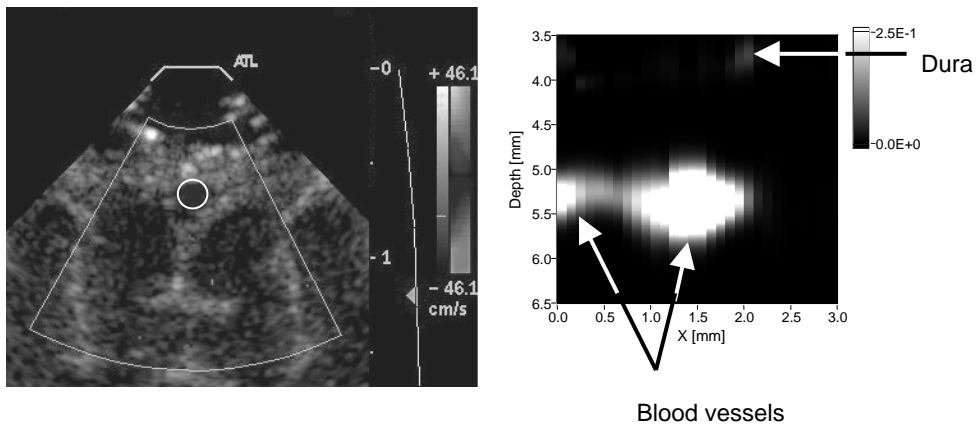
Left panel: color Doppler ultrasound image, showing the blood vessel. The position of the blood vessel is indicated with a circle for clarity. Right panel: photoacoustic reconstruction of a blood vessel in the brain, at a depth of about 1.8 mm below the dura. The gap (about 3.7 mm) between the dura and the photoacoustic sensor was filled with ultrasound contact gel to ensure good acoustic coupling. The position depth=0 mm in the image corresponds with the position of the sensor-surface.
